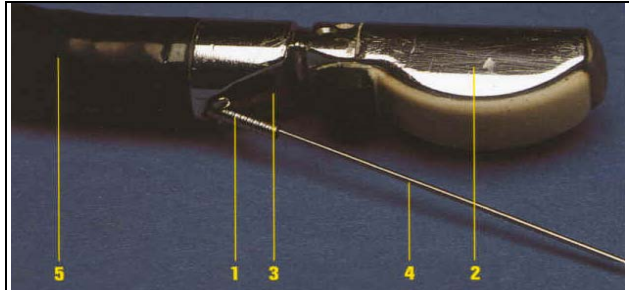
Endoscope with typical components labeled 1. Sheath, 2. Ultrasound transducer, 3. Optic lens, 4. Steel needle, 5. Distal flexible end of the endoscope. (Source: Endosonography.dk⁴)
